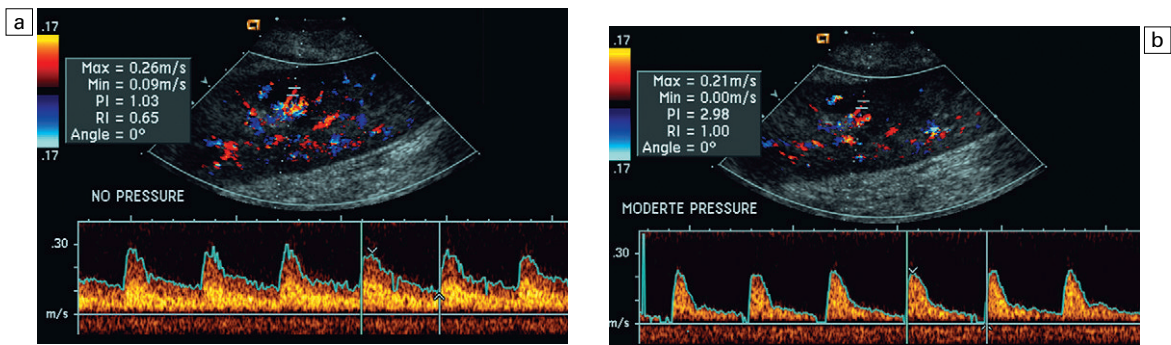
(a) Renal transplant interlobar artery spectral Doppler tracing acquired with gentle transducer contact. Note the normal waveform and 65% resistive index. (b) When moderate pressure is applied by the transducer, the tracing of the same artery now exhibits an elevated resistive index of 100%. Transducer pressure alone is responsible for this increase in vascular impedance and resultant elevation of resistance.
